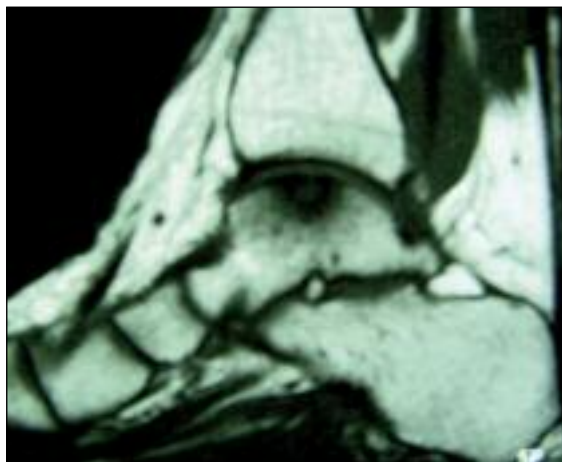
MRI showing talar dome fracture.
